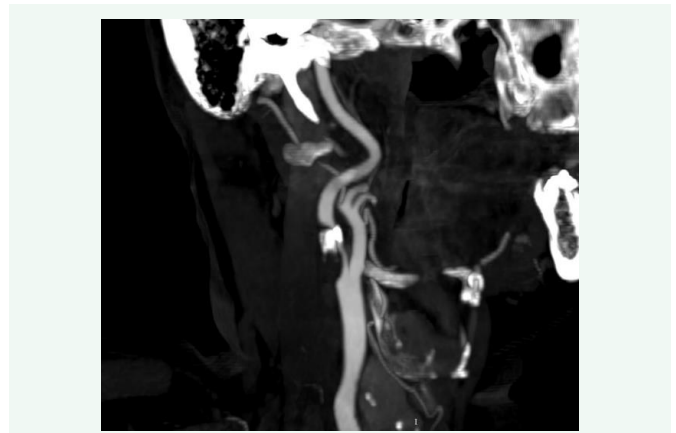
Sagittal CTA showing marked tortuosity of the cervical right internal carotid artery, an anatomical feature associated with increased technical complexity during carotid artery stenting.
